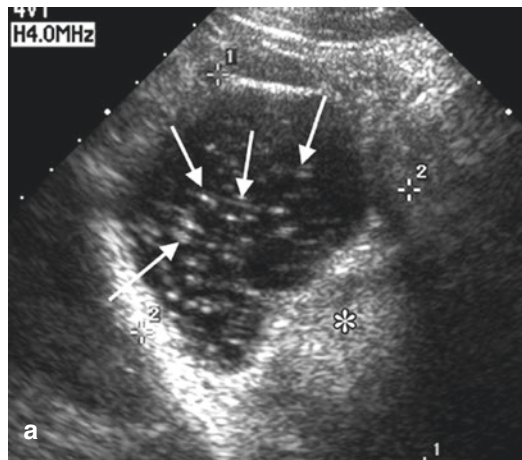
Endometrioma ultrasound study (note the homogenous, low-level echoes “ground-glass” appearance)
